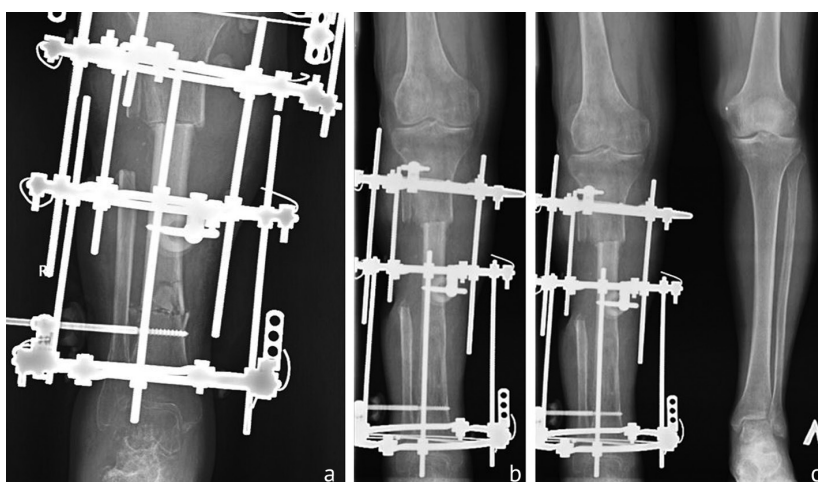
Radiographs: (a) right tibia after osteotomy; (b) right tibia in the course of lengthening; (c) both tibiae after lengthening of the right tibia
